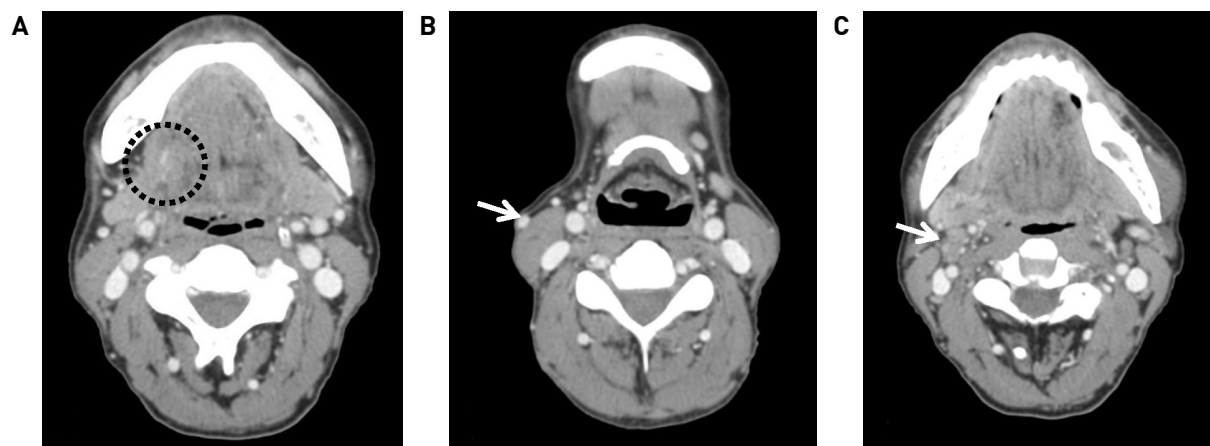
Axial view of the computed tomography scan. (A) Ill-defined oral tongue lesion at right lateral tongue. (Black dotted circle), (B) Enlarged lymph nodes at right neck level Ia (8.5 x 6.7 x 6.5mm, white arrow), (C) Enlarged lymph nodes at right neck level IIa (10 x 7.7 x 13 mm, white arrow)
